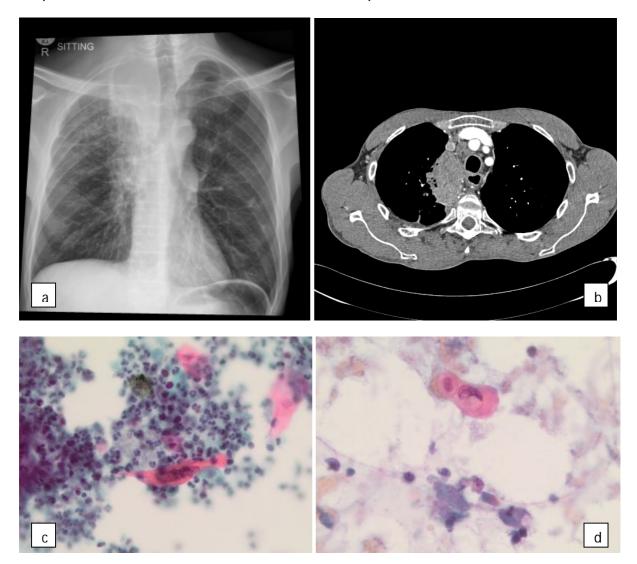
Right apical mediastinal mass with extension into the right hilum with a right nodal mass complex on chest X-ray (a) and CT (b). Sputum – malignant.
